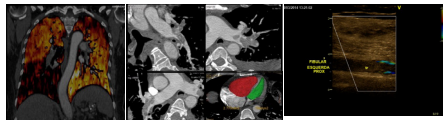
Angio CT with dual Energy depicting pulmonary embolism. Figure 2 – Angio CT depicting filling defects in the pulmonary arteries. Figure 3 – Duplex scan of distal vein with thrombosis.
